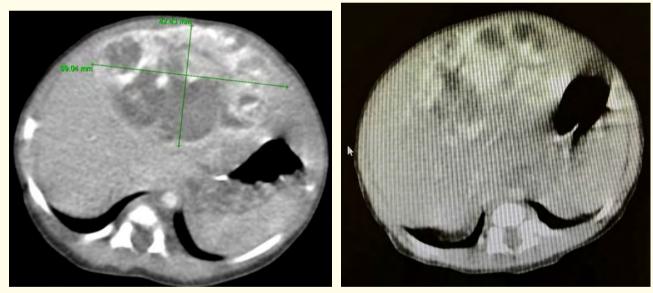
Liver CT in arteria phase.
